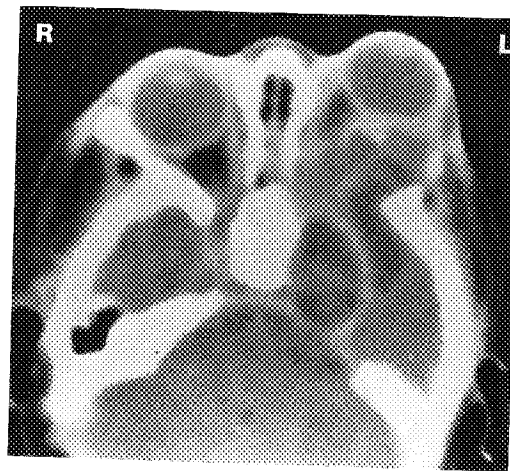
CT scan of orbital teratoma. Note the defect in the left sphenoid bone, with extension of the heterogeneous, retrobulbar, multicyclic mass lesion into the temporal globe (Courtesy of D.H. Birstadt, M.D., Springfield, Illinois.)
